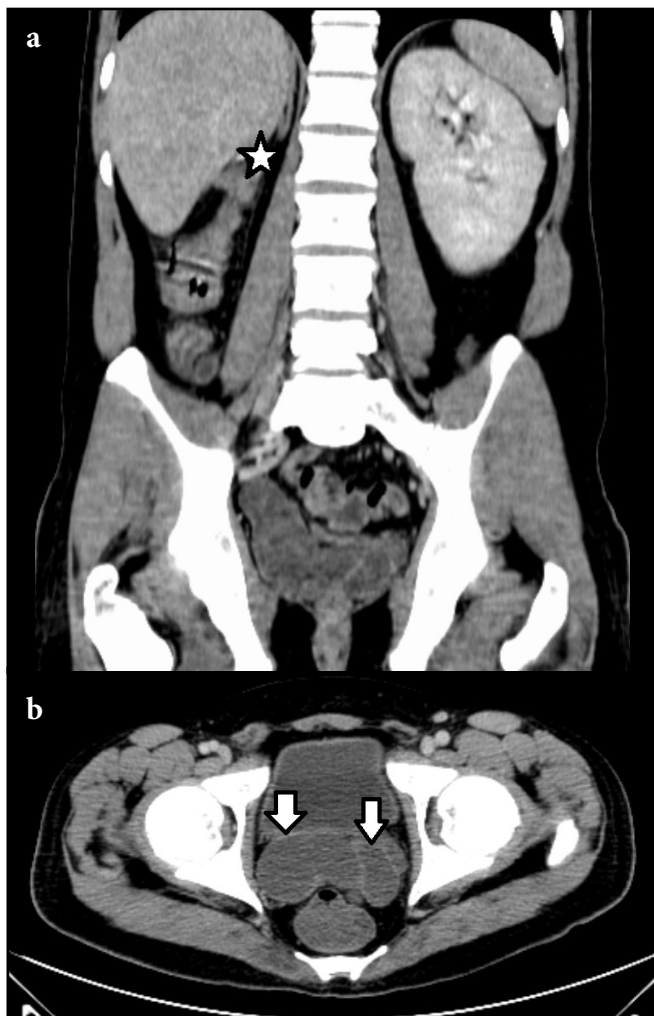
In the CT examination of 36 y.o male patients; On the right, renal agenesis was observed(a) and a cystic lobular lesion was observed at the level of the seminal vesicle (b).
